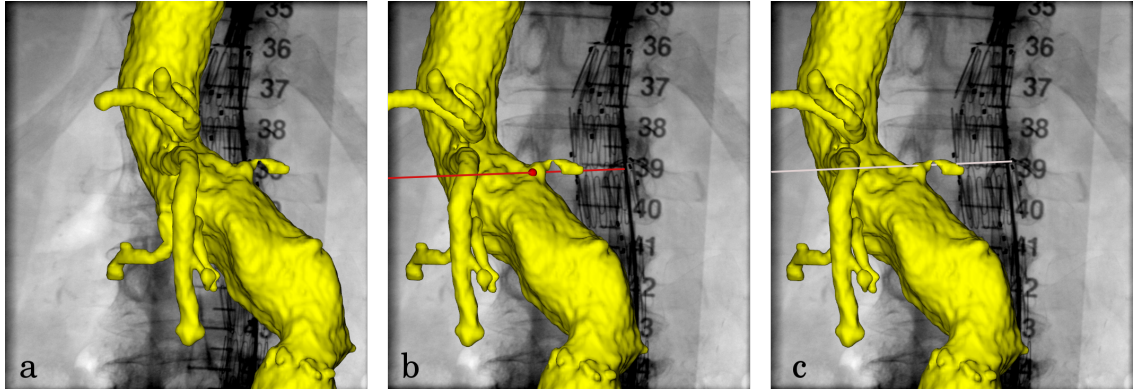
a) Overlaying a surface rendering of the CT aorta lumen and visceral vessels onto the fluoroscopy image using the registration final position. The surface can be rotated to provide some 3D information as seen in ‘b’ and ‘c’. In addition, in b), a point on the surface is picked (red point) to be projected onto the fluoroscopy image; whereas in c), a point on the fluoroscopy image is picked to be back projected onto a line through the surface (white line).
